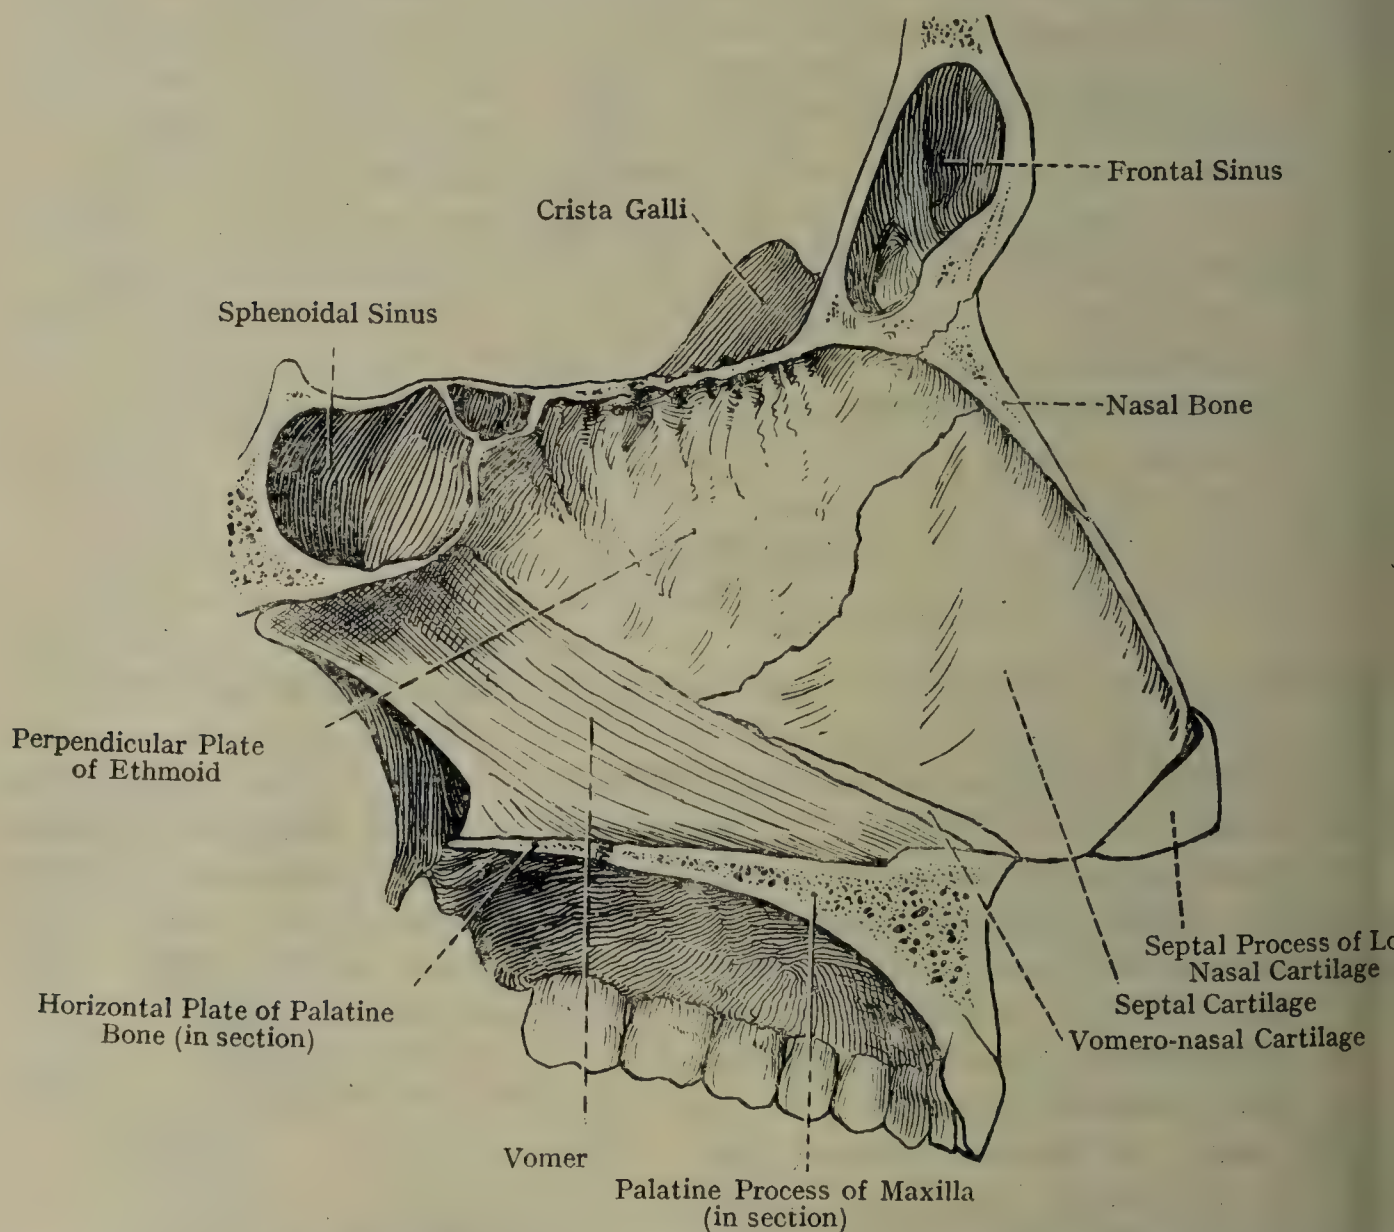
THE OSSEOUS AND CARTILAGINOUS NASAL SEPTUM (RIGHT LATERAL ASPECT).
